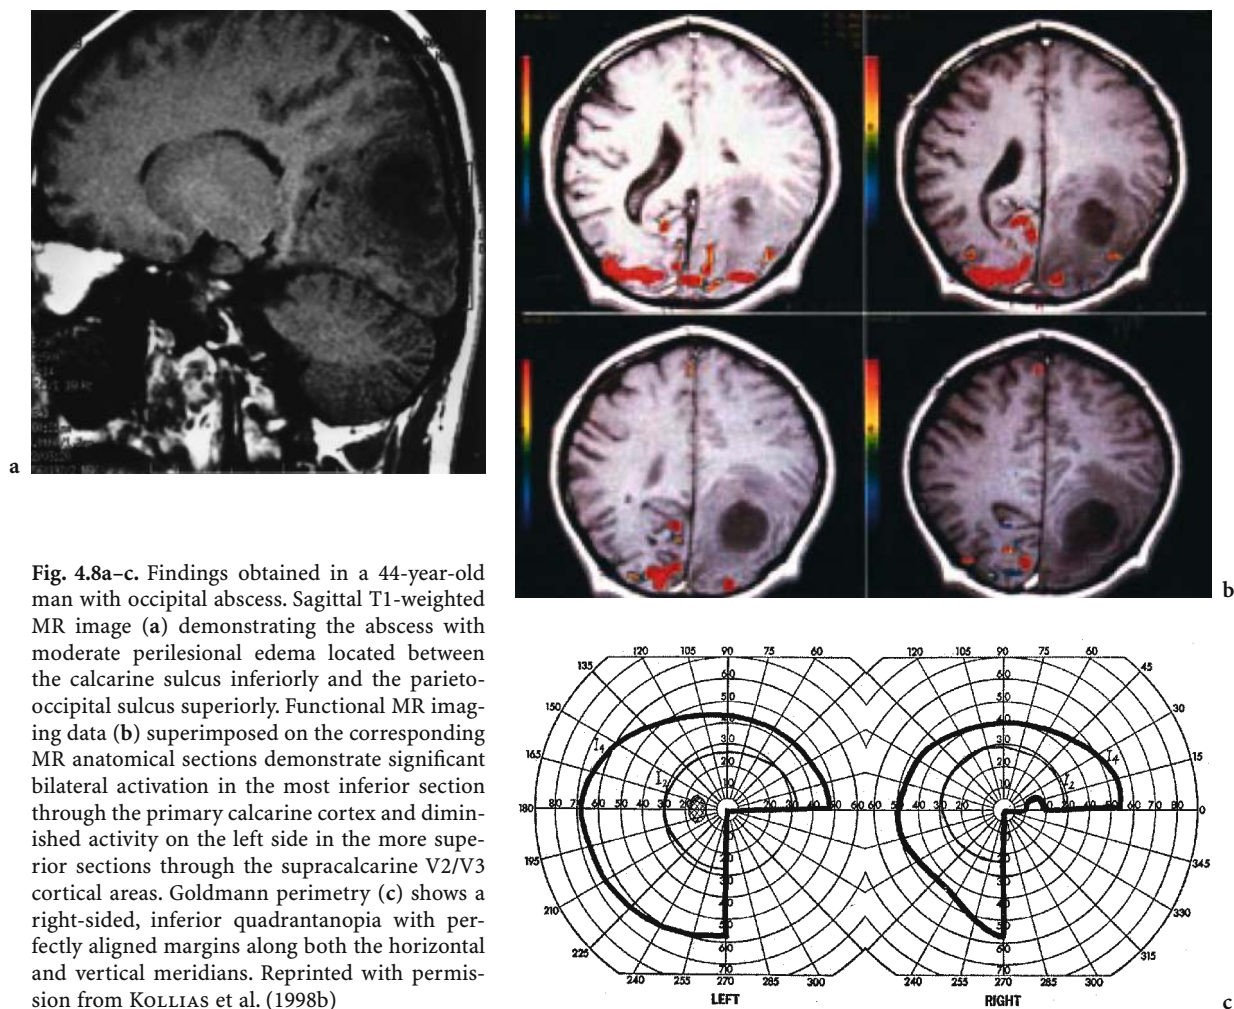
Findings obtained in a 44-year-old man with occipital abscess. Sagittal T1-weighted MR image (a) demonstrating the abscess with moderate perilesional edema located between the calcarine sulcus inferiorly and the parieto-occipital sulcus superiorly. Functional MR imaging data (b) superimposed on the corresponding MR anatomical sections demonstrate significant bilateral activation in the most inferior section through the primary calcarine cortex and diminished activity on the left side in the more superior sections through the supracalcarine V2/V3 cortical areas. Goldmann perimetry (c) shows a right-sided, inferior quadrantanopia with perfectly aligned margins along both the horizontal and vertical meridians. Reprinted with permission from KOLLIAS et al. (1998b)
